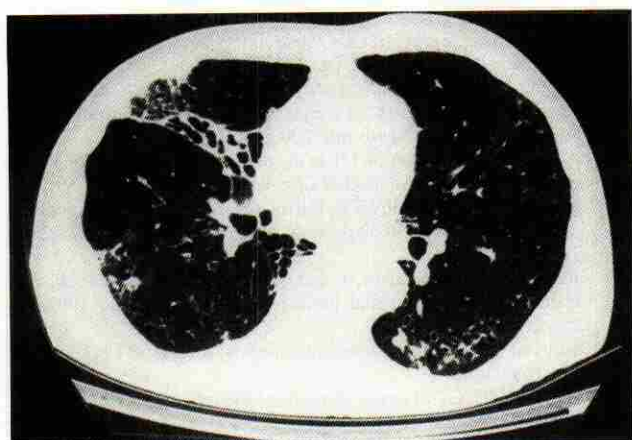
High-resolution computed tomogram of patient with bronchiectasis and *Mycobacterium avium-intracellulare* infection. Note changes of bronchiectasis and adjacent nodular infiltrates characteristic of this disease.
